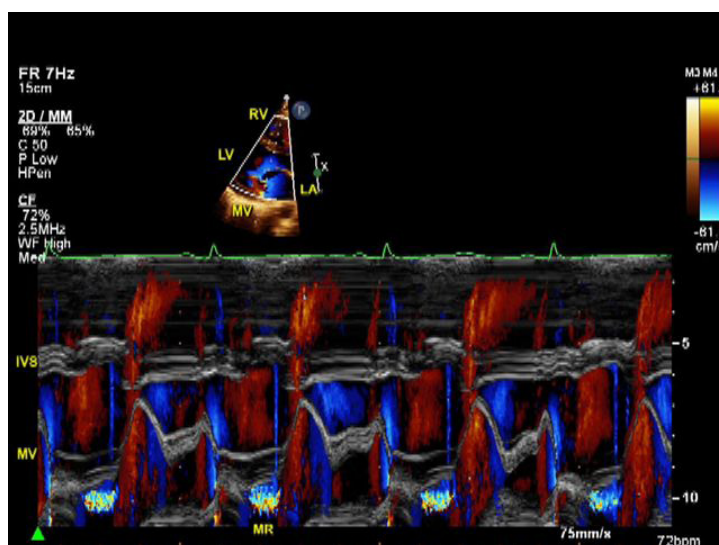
M-mode transthoracic echocardiogram in the parasternal long-axis view shows mid to late systolic MR in a patient with MV prolapse. IVS: interventricular septum; MR: mitral regurgitation; MV: mitral valve; LV: left ventricle; LA: left atrium; RV: right ventricle. Copyright with Aiman Smer
